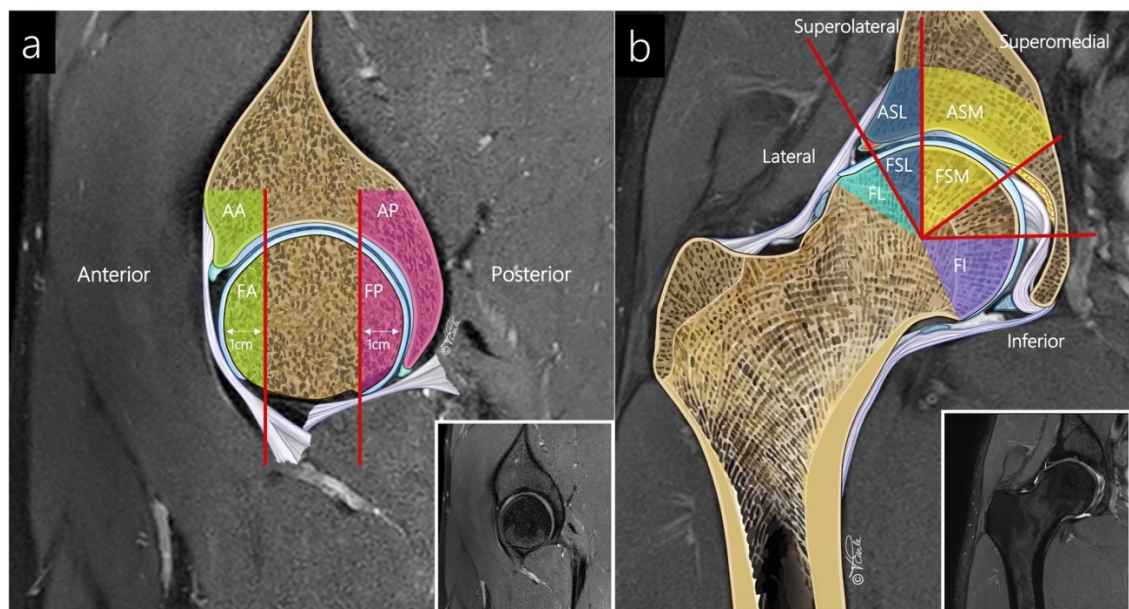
Sagittal and coronal magnetic resonance images with anatomic detail (original image inset) of acetabular and femoral subregions.
